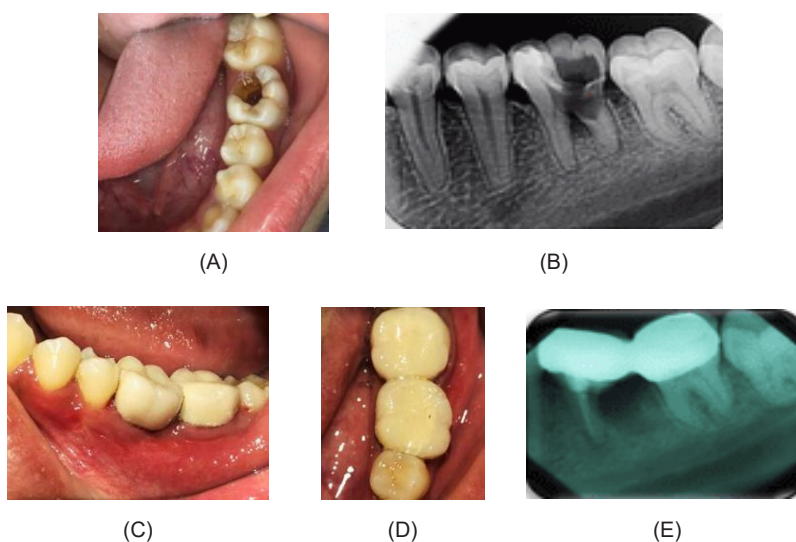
Clinical and radiographic photos before and after treatment: (A) clinical photo before treatment; (B) pre-treatment radiograph; (C) clinical photos after treatment from buccal views and (D) occlusal views; (E) radiograph after treatment.
